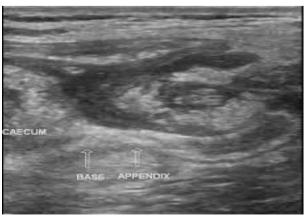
Fig IV Ultrasound Scan in Perforated appendix
